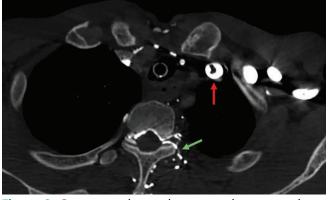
Contrast-enhanced computed tomography noted thrombosis in the left brachiocephalic vein (red arrow) and contrast filling of the paravertebral veins, usually occult on contrast enhancement (green arrow).
